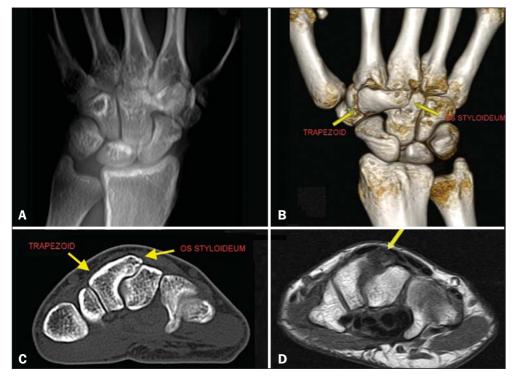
A: Digital X-ray showing a lack of definition of the joint space between the trapezoid and the capitate. B,C: Three-dimensional computed tomography reconstruction and axial computed tomography slice showing an os styloideum fused to the trapezoid and in neoarticulation with the capitate. D: Magnetic resonance imaging in a T1-weighted sequence, showing os styloideum with bone edema adjacent to the neoarticulation (apophysitis).
